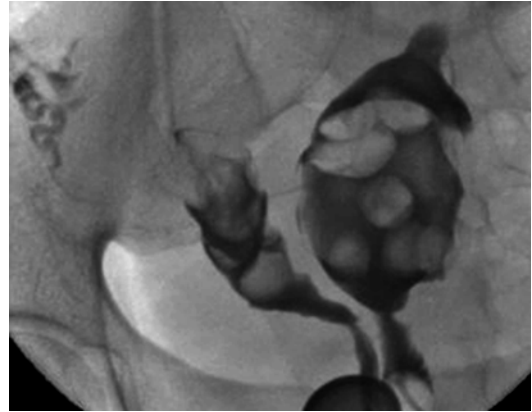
Severe fibroid disease in a bicorporeal system. Extensive fibroid disease diagnosed on MRI and ultrasound. HSG confirmed the presence of a complete bicorporeal system, uterus didelphys U3b C2 V2
